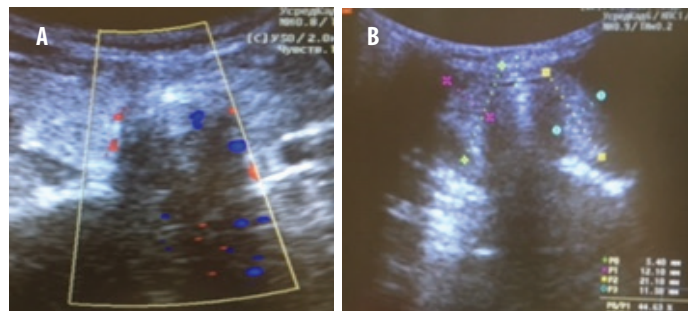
Patient M., group IA (Tazalok™): ultrasound normalization thyroid tissue density
